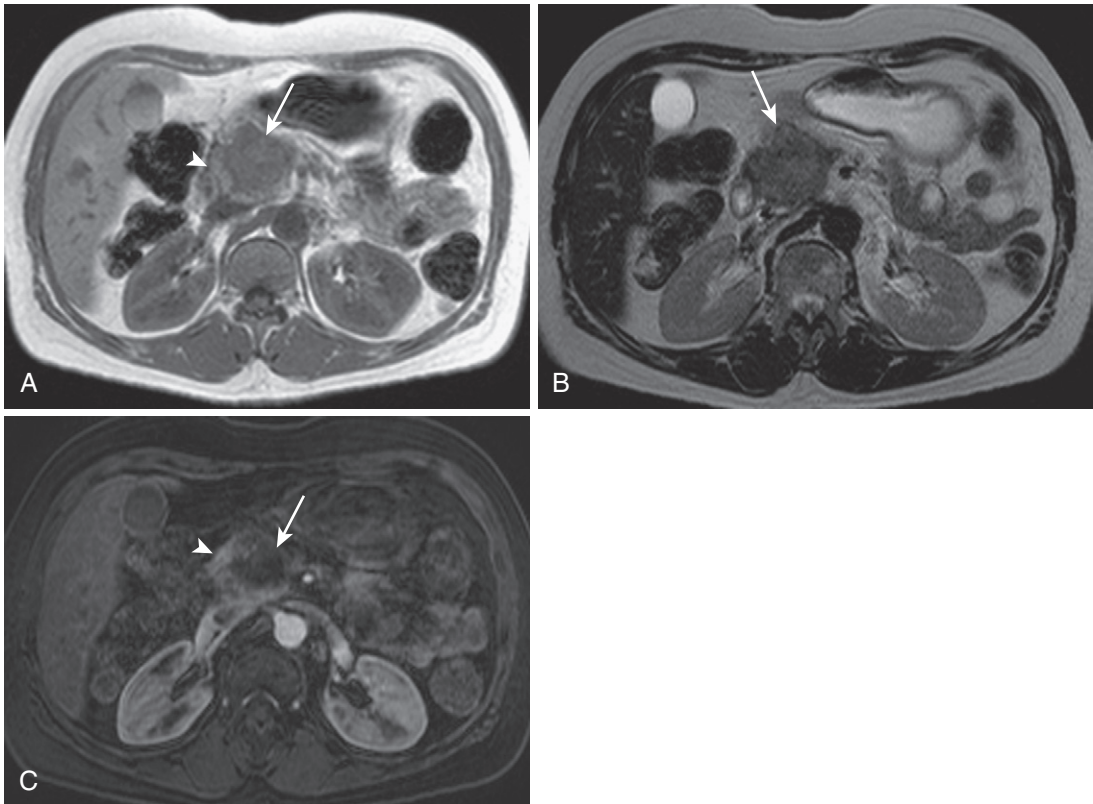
Pancreatic adenocarcinoma. A, The in-phase (T1-weighted) image in a patient with pancreatic adenocarcinoma in the pancreatic head (*arrow*) shows relative hypointensity compared with normal parenchyma (*arrowhead*). B, The T2-weighted image exemplifies the usual hypointensity (*arrow*) with little contrast between normal tissue and neoplasm. C, The enhanced image bears the highest tissue contrast between the lesion (*arrow*) and normal pancreatic tissue (*arrowhead*).
